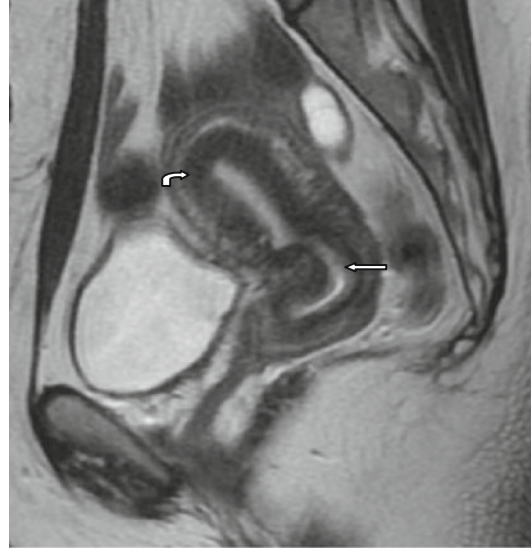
Normal uterus; sagittal T2-weighted MRI clearly depicting the zonal anatomy of the uterus with the three zones displayed: intermediate signal of the endometrial lining (*straight arrow*), low signal of the junctional zone, i.e., the inner myometrium (*curved arrow*), and intermediate signal of the outer myometrium
